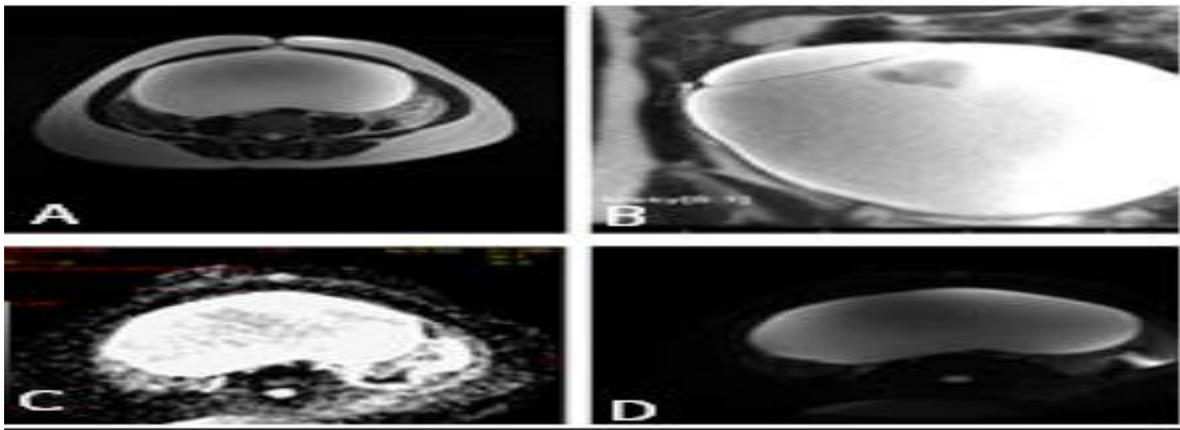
A case of left Serous ovarian cystadenoma , (A) Axial T2 weighted image, (B) coronal T2 weighted image, (C) Axial ADC image, (D) Axial T2 - fat suppression, the lesion elicits fluid iso- equivalent signal alteration, containing areas of predominant fluid signal, appears as low T1 & high T2 signal and being not suppressed in T2 fat suppression WIs with facilitated diffusion in DWI and high corresponding ADC values $3.1 \pm 0 \times 10^{-3} \text{ mm}^2/\text{s}$, P value 1000.
